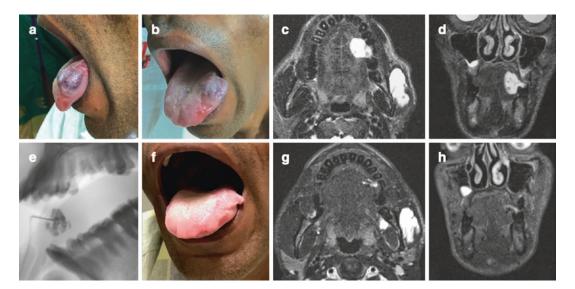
A 30-year-old male presented with swelling in the tongue causing pain. (\mathbf{a} , \mathbf{b}) Preoperative clinical photograph showing a purplish bluish soft swelling on the left lateral aspect of the tongue. (\mathbf{c} , \mathbf{d}) Preoperative T2 weighted magnetic resonance imaging axial and coronal section showing hyperintense venous malformation in the left lateral side of the tongue and incidentally detected left masseteric Venous malformation. (permucosal sclerotherapy was performed. (\mathbf{e}) Plain radiograph in lateral view
